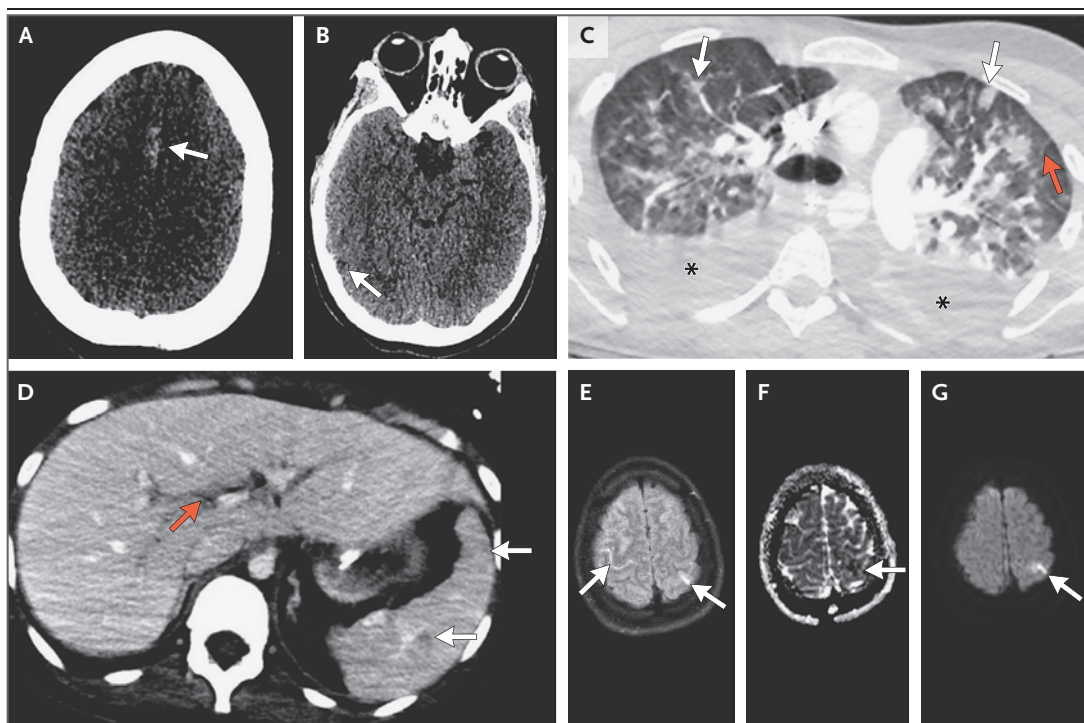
CT and MRI Images.
